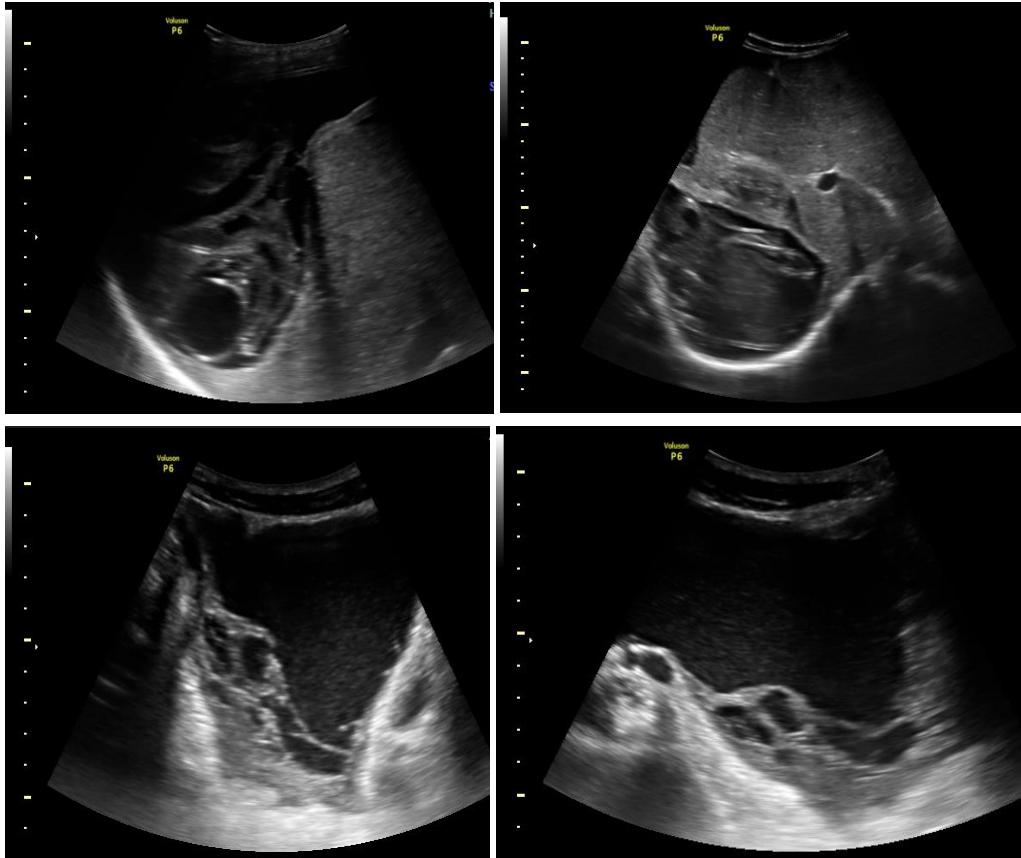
Pictures of ultrasound exam demonstrating a cystic formation in both of liver and pelvic
